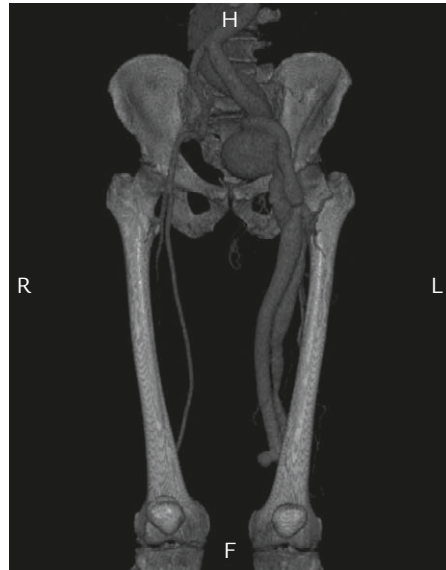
Multiple-detector computed tomography angiography of the arteriovenous fistula reveals dilatation of the femoral and iliac veins of the left lower limb, indicating arteriovenous fistula at the level above the left knee.
